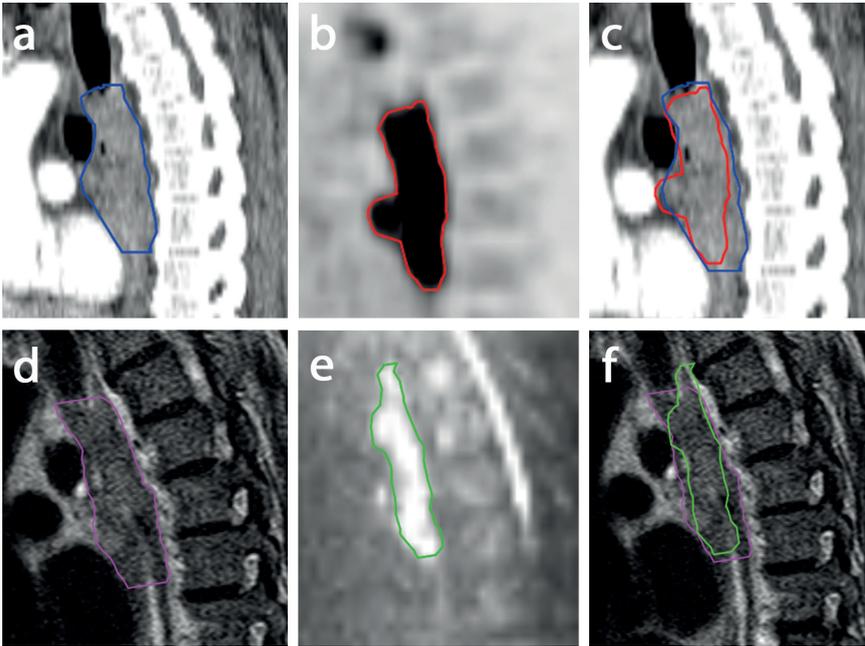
(a) Delineation of the gross tumor volume (GTV) for radiation treatment planning in esophageal cancer is generally performed on a low-dose contrast-enhanced CT (*blue contour*). (b,c) Corresponding ^{18}F -FDG PET may aid to determine the biologically active volume and subsequently alter the shape and volume of the GTV (*red contour*). (d) T2-weighted MRI provides higher soft-tissue contrast resolution compared to CT and may allow for further target definition improvement (*pink contour*). (e,f) Similar to ^{18}F -FDG PET, DWI ($b=800 \text{ s/mm}^2$) may provide a better reflection of the true (functional) malignant volume and cranio-caudal length (*green contour*).
